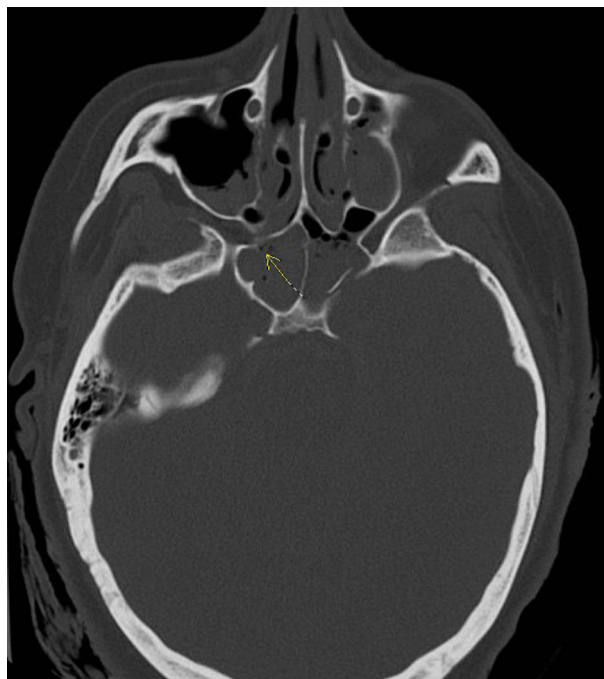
Axial view of the head CT. (Yellow arrow: right sided anterior sphenoid wall fracture due to force of penetrating trauma).
